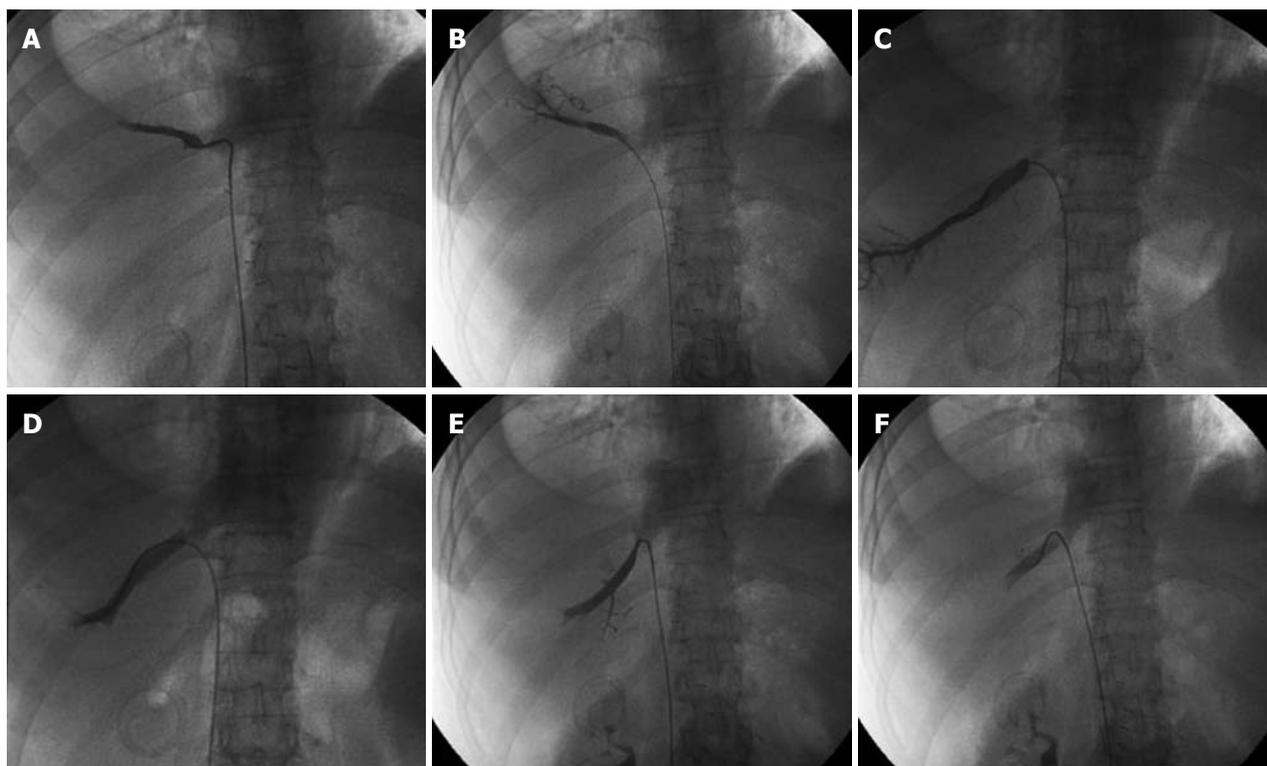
Status post deceased donor right lobe split LT in 65-year-old female. Three separate HV anastomoses were performed. One month after LT, patient developed refractory ascites and right pleural effusion with worsening of liver function tests. Doppler US was suspicious of HVs. A cavogram performed from the femoral approach showed widely patent IVC anastomosis. Selective catheterization of the three HVs (A, C and E) showed stenosis in the three anastomoses with trans-stenotic pressure gradient of 15, 20 and 16 mmHg, respectively. Balloon angioplasties were performed with balloon catheters ranging from 7 to 10 mm in diameter. Final venogram showed patent anastomoses (B, D and F). Trans-anastomotic pressure gradient reduced to 4, 2.5 and 8 mmHg. Eight months of follow-up without recurrence of refractory ascites and/or hydrothorax.
